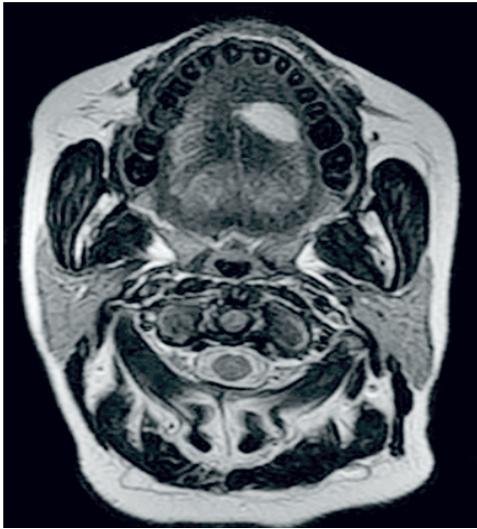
MRI (Axial T2 FSE) image showing heterogenous intralingual mass with high signal intensity
